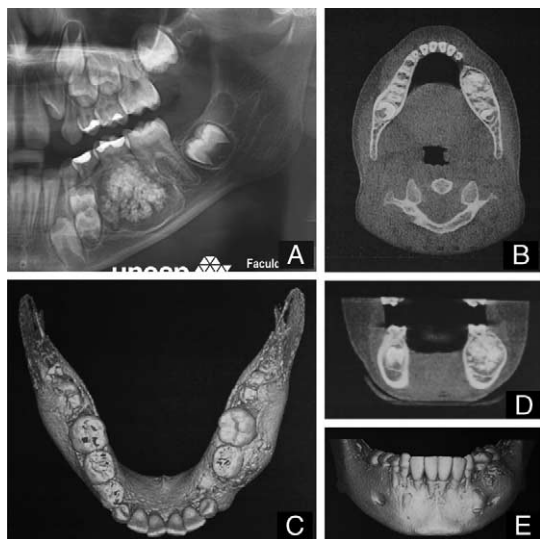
Radiographic image (A), CT scan (B and D), and three-dimensional reconstruction (C and E).
